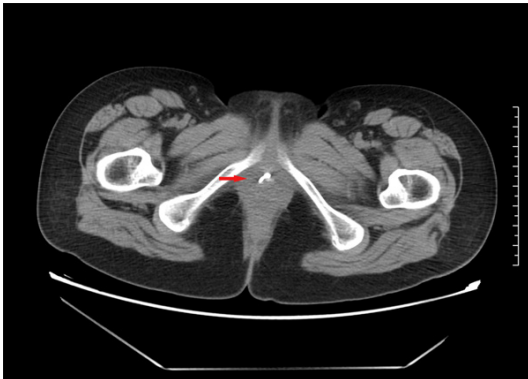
On pelvic CT, the IUD can be seen partially sunk into the neck of bladder (red arrow).
